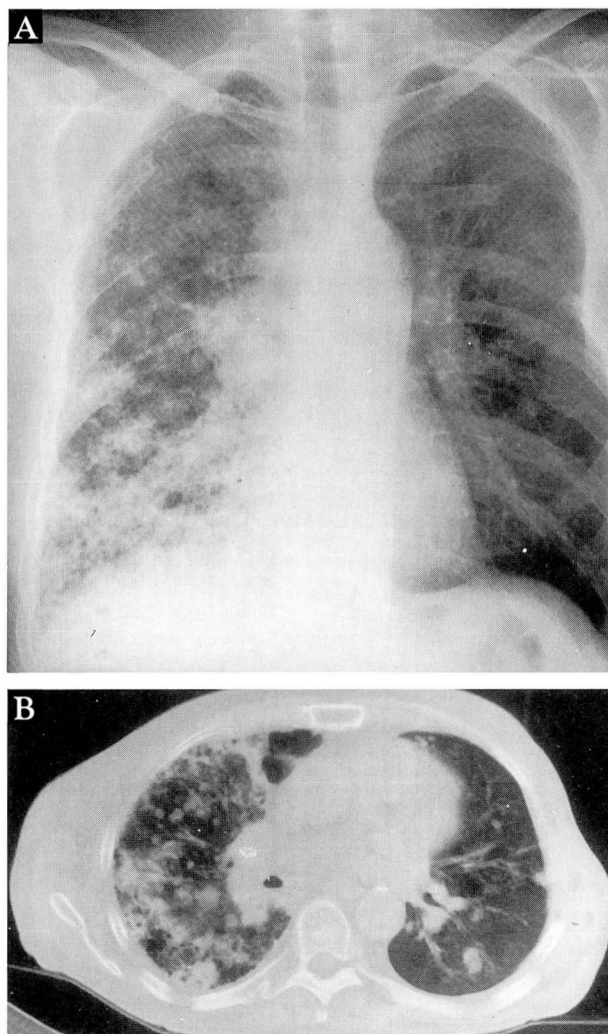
Chest roentgenogram (A) and computed tomographic scan of the chest (B) in a patient with left single-lung transplantation for idiopathic pulmonary fibrosis who contracted invasive aspergillosis infection in the fourth month after transplantation.
